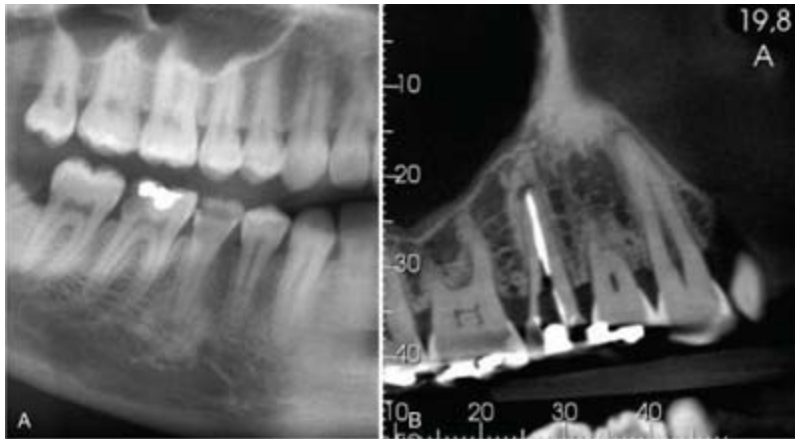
A, Cropped panoramic image of condensing osteitis exhibiting a widened PDL space with a radiodense rim at the apex of a carious tooth #29. B, Sagittal CBCT image of maxillary premolar with previous endodontic treatment. A homogeneous high-density lesion is present with circumferential loss of density at the root apex suggesting an inflammatory etiology.
